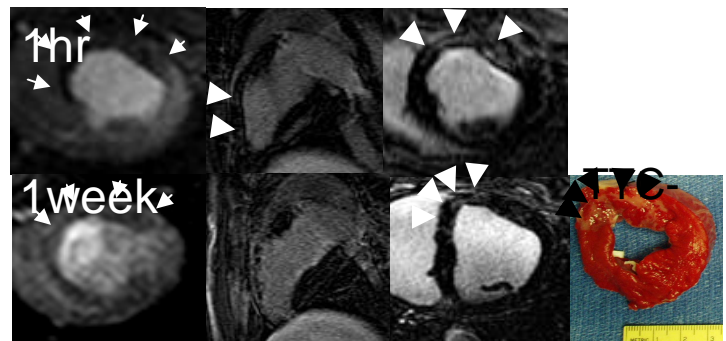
MR images at 1hr (top) and 1week (bottom) show the heterogeneous embolized region on first pass of Gd-DOTA (left) and on delayed contrast enhancement in long (middle) and short (right) axis views. Note the perfusion deficit is greater at 1hr than at 1 week (left images, arrowheads). Corresponding TTC (right) slice shows discrete microinfarction in anteroseptal wall (arrows).
